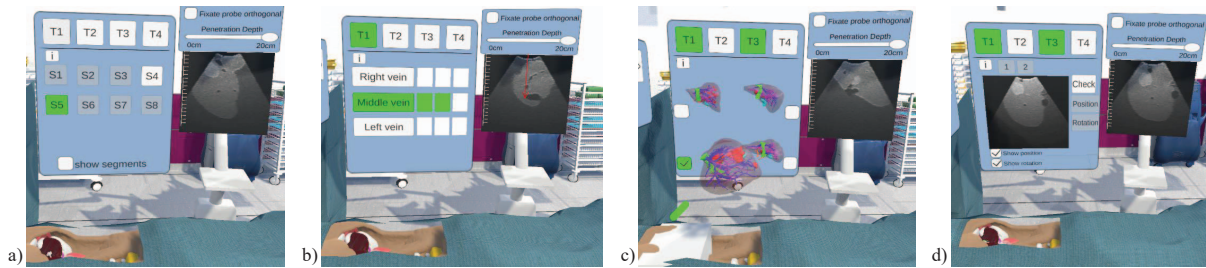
Immersive virtual reality training environment for intraoperative liver ultrasound. Training scenarios include (a) identification of liver segments, (b) scanning veins, (c) transfer of ultrasound to 3D model, (d) and probe handling.
